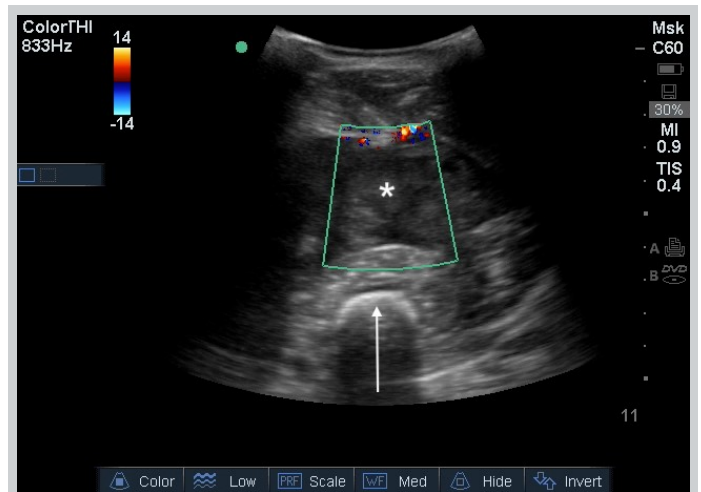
Ultrasound color Doppler image of a large hematoma (asterisk) in the anterior thigh, appearing as a well circumscribed collection of mixed echogenicity without vascularity. The femur (arrow) is the hyperechoic structure with posterior shadowing.
